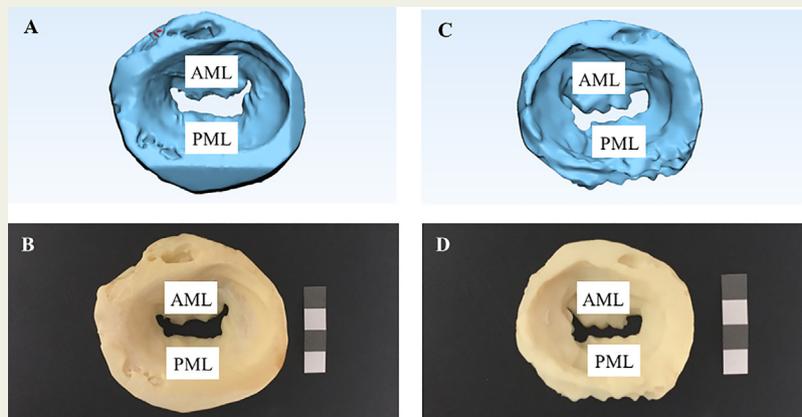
Virtual and 3D printed MV models for patient 2 with MV disease associated with an aortic perforation. Cardiac CT and 3D echocardiography imaging data was used to produce virtual 3D models (A and C respectively), which were 3D printed using fused deposition modelling (B and D respectively) to compare 3D printed models produced from different imaging modalities. Abbreviations: 3D, three dimensional; MV, mitral valve; AML, anterior mitral leaflet; PML, posterior mitral leaflet. [Note: calibration inset, 10 mm x 10 mm squares].
